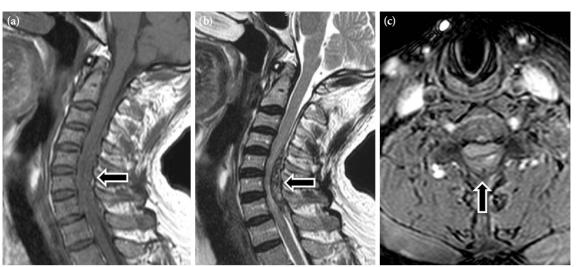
A preoperative magnetic resonance imaging showing a posterior spontaneous spinal epidural hematoma located from C4 to T1 level. (a) The mass having isointensity to spinal cord on T1-weighted and (b) heterogeneous signal intensity to spinal cord on T2-weighted sagittal scanning images and (c) spinal cord compression on dorsal and left lateral sides on T2-weighted axial scanning image.
